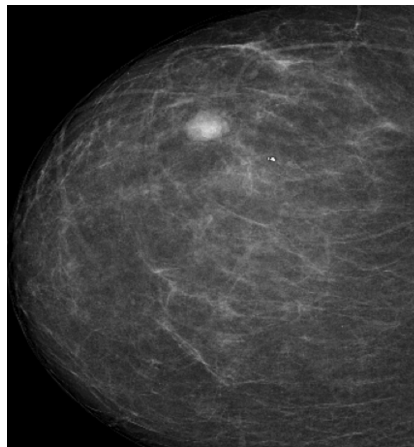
An initial mammogram identified a focal asymmetry. Sonography later determined it to be a cyst.
